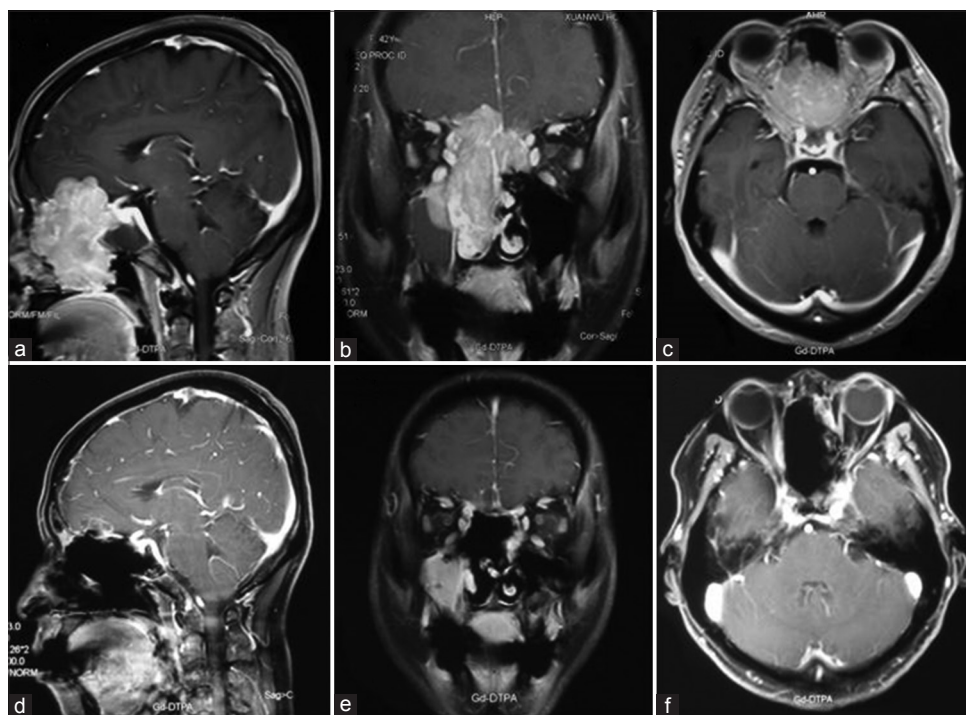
Preoperative sagittal (a), coronal (b), and axial (c) enhanced MRI demonstrated a giant enhanced intra- and extracranial lesion which extended from the frontal recess and posterior table of the frontal sinus to the tuberculum sellae with no surrounding edema. Postoperative sagittal (d), coronal (e), and axial (f) enhanced MRI at 20 days after surgery showed that the tumor had been completely removed. MRI: Magnetic resonance imaging.
